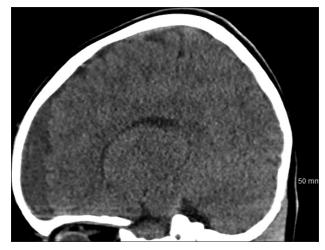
CT head sagittal 3 months postsurgery demonstrating significantly improved appearance of previously compressed left frontal cortex.
